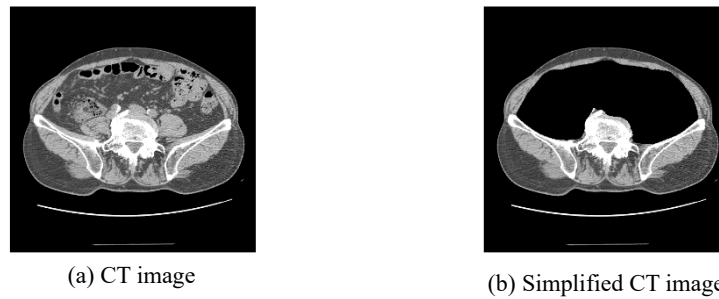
Example of the original image and a simplified CT image.
